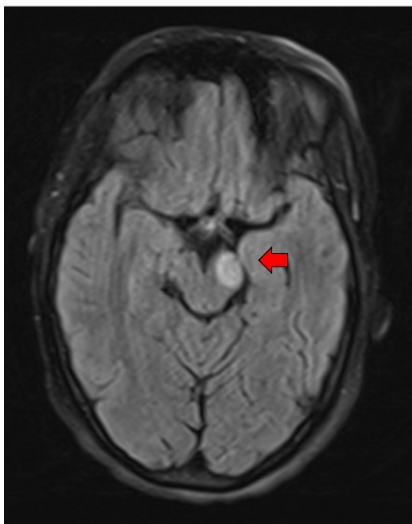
Midbrain FLAIR in axial plane
